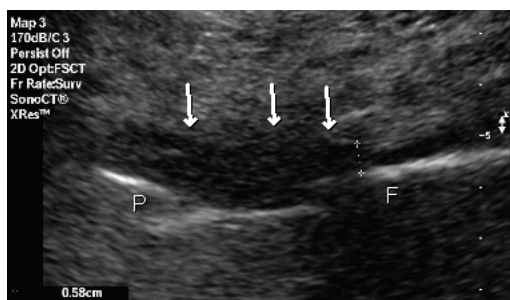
Sagittal anterior sonographic appearance of a hip prosthesis. Arrows show normal anterior part of the post-operative capsule in front of the prosthetic head (P) and the proximal femur (F). Callipers indicate bone-to-capsule distance.
